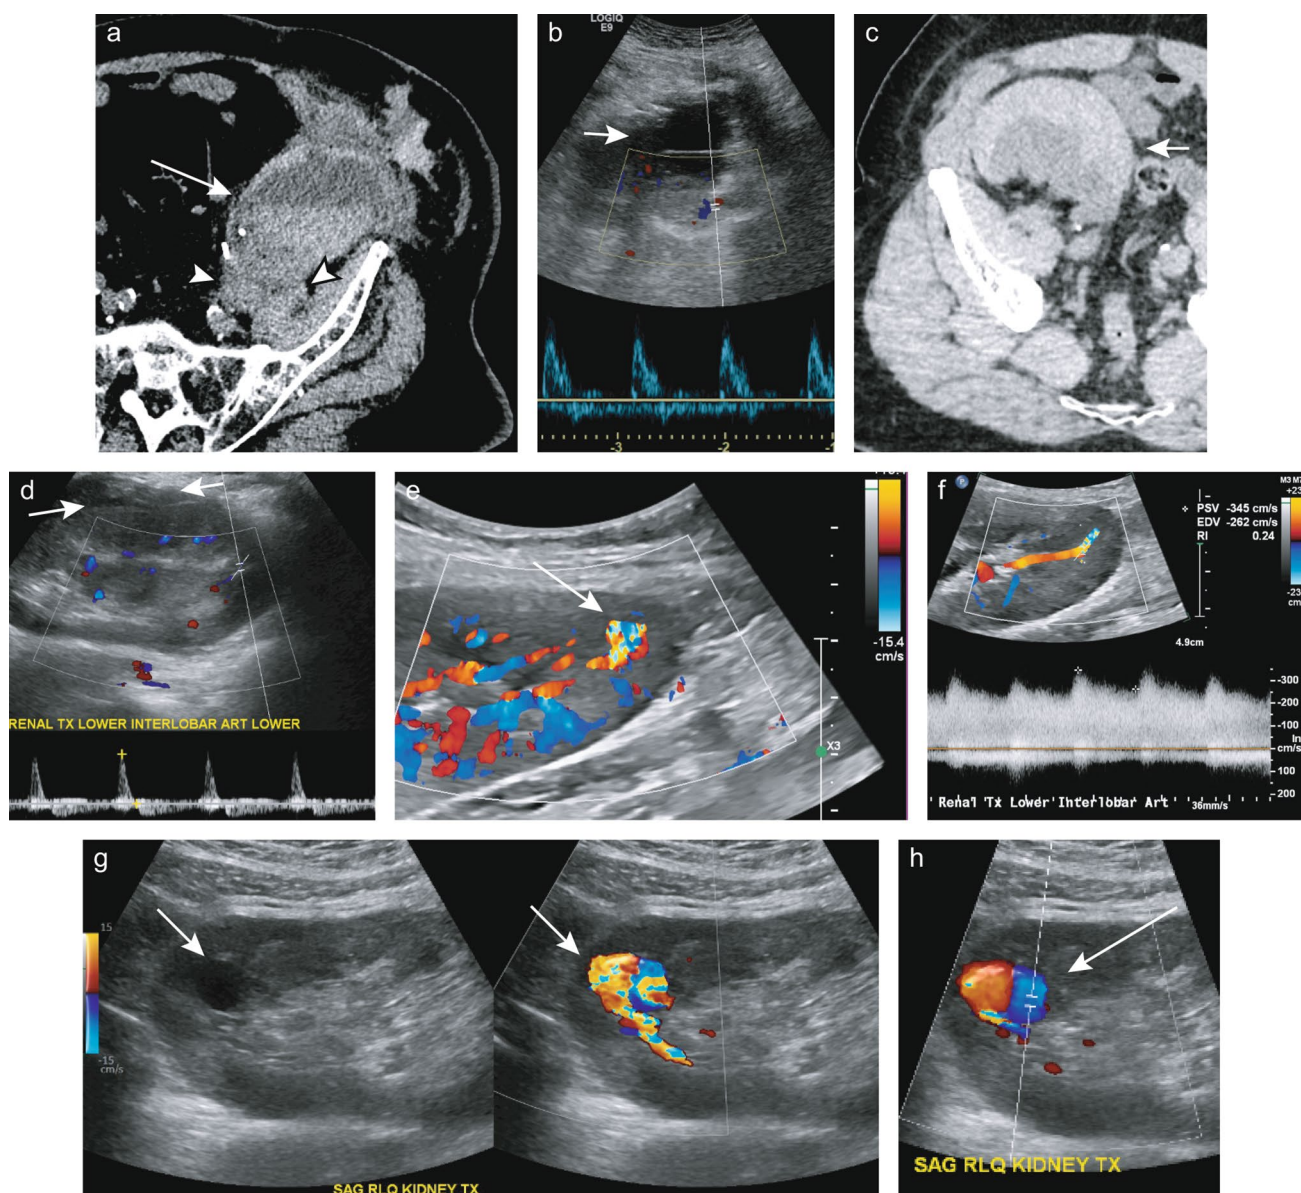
Vascular injuries and consequences. a CT performed day-of-surgery with a large, layering hematoma (arrow) displacing and compressing the graft kidney posteriorly (arrowheads). b Immediately subsequent ultrasound showing the hematoma (arrow) and high resistance waveform with diastolic reversal in the renal arcuate arteries, indicating RACS. c Non-enhanced CT after ultrasound-guided cortical biopsy showing a crescentic, hyperattenuating collection compressing the renal cortex and effacing
